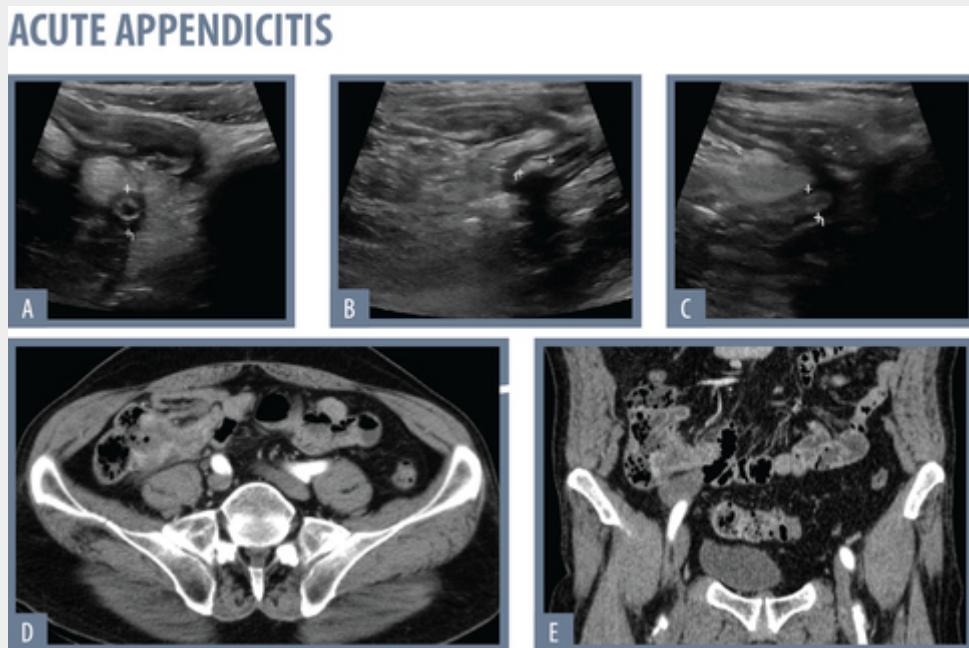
A),B) and C) ultrasound revealing appendiceal wall thickening, as well as periappendiceal fluid. There is also a hyperechoic shadow-casting image corresponding to an appendicolith. D) and E) are the corresponding CT images
